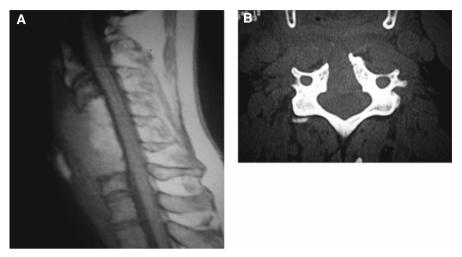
Anatomical result after median somatotomy without graft. A MRI: the T1 hypersignal from C3 to C7 corresponds to the fibrous scar. B CT: aspect of the bone trapezoidal resection
